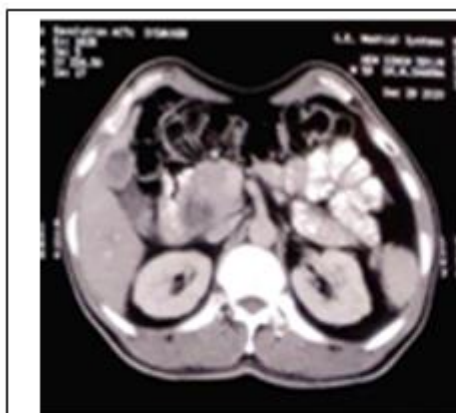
CT image showing ill-defined mass In relation to D2 with thickening of neck of gall bladder
